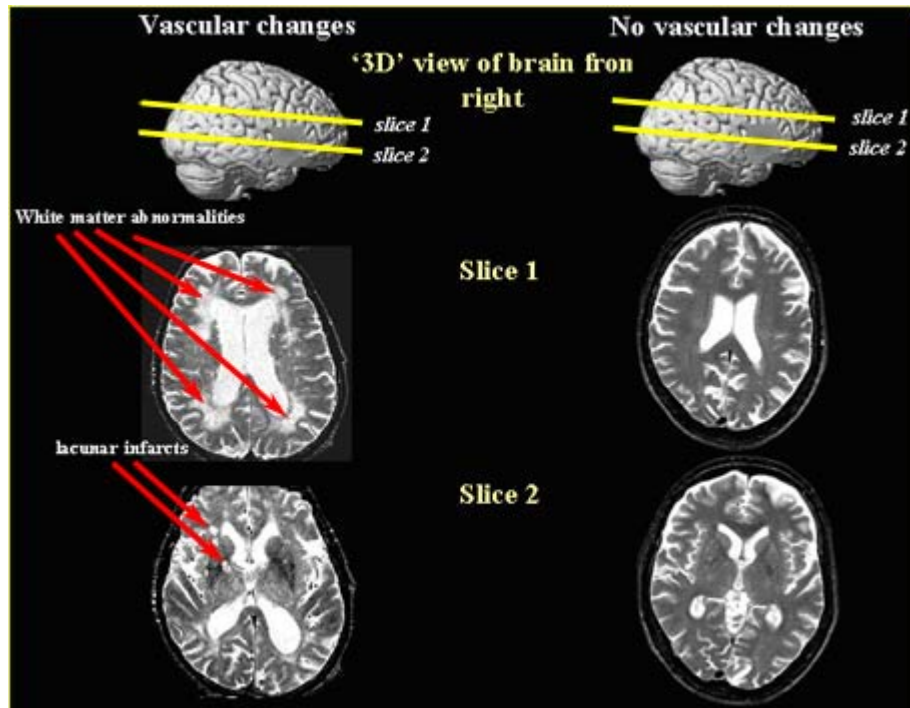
MRI from patients with (left) and without (right) abnormalities of the type seen in VaD. Images on the bottom are single MRI 'slices' through the brain. The top images are three dimensional views of the brain, with the yellow lines denoting the location of the slices below.
